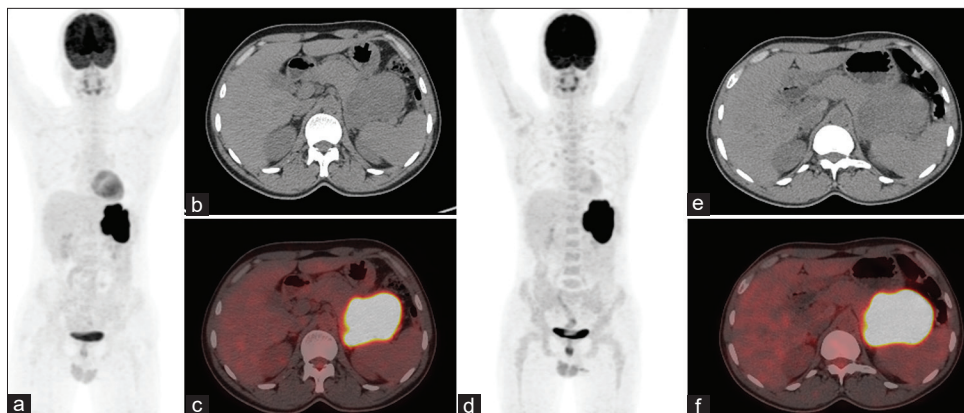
Case of 32-year-old male who diagnosed with Gastro Intestinal Stromal Tumor and underwent Baseline Positron emission tomography/computed tomography (MIP [a], Axial computed tomography [b], Axial Positron emission tomography/computed tomography [c]); which revealed a metabolically active mass involving the body of the stomach and no other site of involvement. The intense uptake was indicative of malignant nature of the disease. He was started on Imatinib based chemotherapy and underwent Positron emission tomography/computed tomography after 3 months (MIP [d], Axial computed tomography [e], Axial Positron emission tomography/computed tomography [f]); which revealed mild increase in the extent of the earlier lesion as well as metabolic uptake. Though the increase was not enough to satisfy the criteria of progressive disease and the patient was categorized as having stable disease, it ruled out possibility of surgery and the patient was considered for alternative treatment regimen
